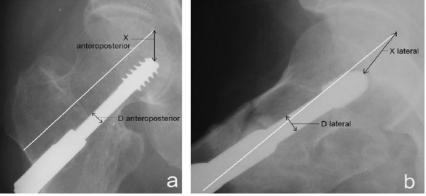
Measurement of the distance between the tip of the lag screw to the apex of the femoral head (X) and the diameter of the lag screw (D) on the (a) anteroposterior and (b) lateral radiographs. (Tip-apex index = X anteroposterior x [True diameter / D anteroposterior] + X lateral x [True diameter / D lateral]). (45) The radiographic magnification is calculated by dividing the known diameter of the screw's projected shaft by a diameter on the radiograph, and the correction is calculated by multiplying the distance measurement by this factor. As end points, the radiographs will evaluate screw cut out, nonunion, and union. (43) The barrel plate angle is determined from the normal side. The most frequently used ideal angle is 135 degrees. There doesn't seem to be any proof that another angle is better. A higher angled blade plate (140)
